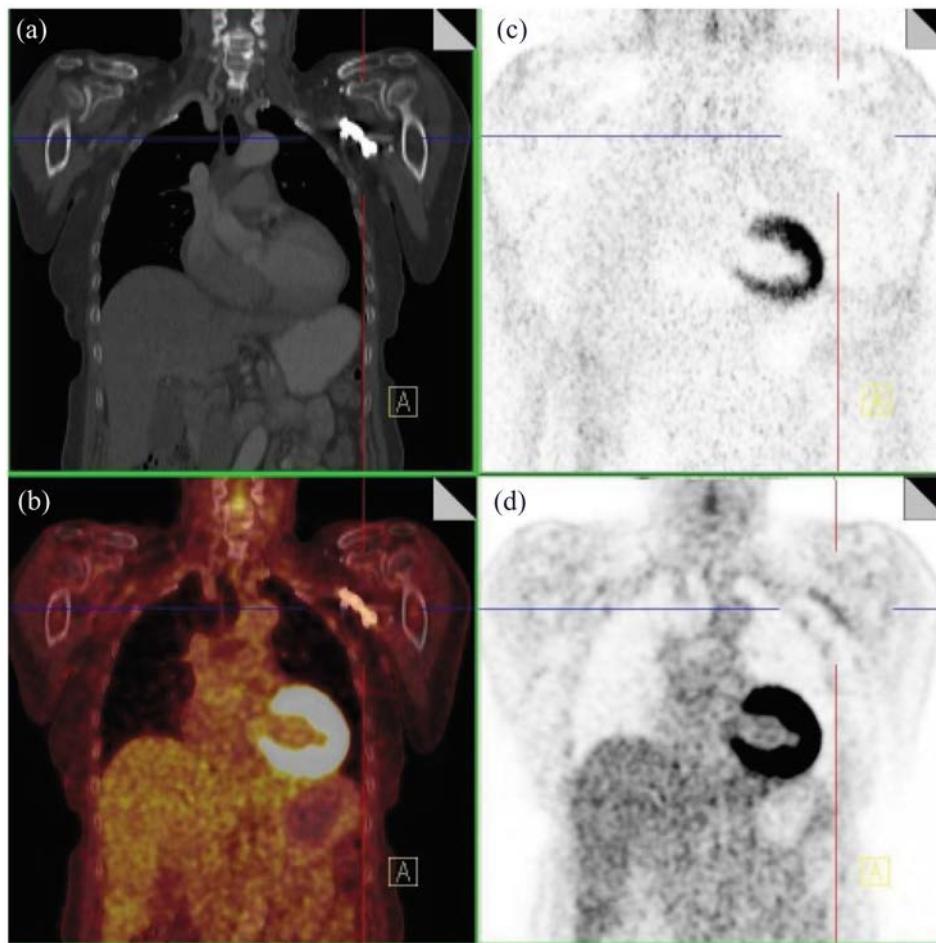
Coronal images of a whole body FDG-PET/CT study with intravenous contrast. (a) CT image shown in bone window; (b) fused AC-PET and CT; (c) uncorrected PET; (d) AC-PET demonstrating hot spot artefacts corresponding to intravenous contrast accumulation. AC: attenuation corrected.
